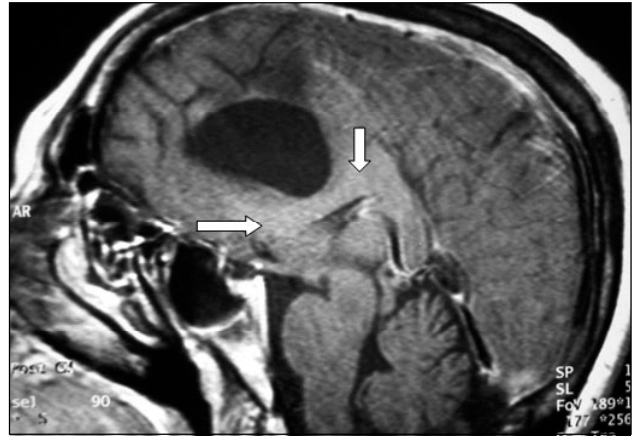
An MRI (T1-weighted sagittal view) showed displacement of the anterior body of the corpus callosum. Cyst dimensions were as follows: 61x65x69 mm. The mass of the AC was believed to be the reason for the symptoms.
